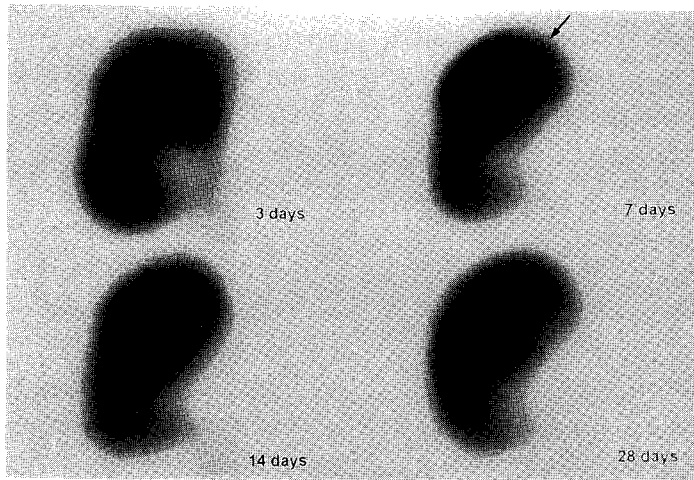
Coronal tomographs of sequential Tc-99m MAG3 renal SPECT studies in a 29 years old woman with double ureters. There is normal distribution of radioactivity throughout the transplanted kidney and good visualization of the double ureters on the initial scan (3 days), but follow-up scans reveals non-visualization of upper ureter and persistent focally increased radioactivity (arrow) in the upper pole.
